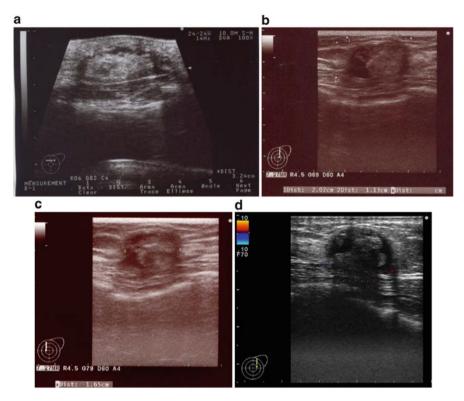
(a) Representative ultrasonography (US) findings obtained 1 month after radiofrequency ablation (RFA) showing a 30 mm-sized hyperechoic oval mass. (b) US performed 3 years after RFA. The ablation zone appears as a 20×10 mm-sized cystic and solid tumor. (c) US performed 4 years after RFA. The ablation zone has reduced to 16 mm in size. (d) Color Doppler ultrasonography performed 5 years after RFA. The ablation zone has been further reduced to 12×10 mm in size, and blood flow is absent within the internal hyperechoic region
